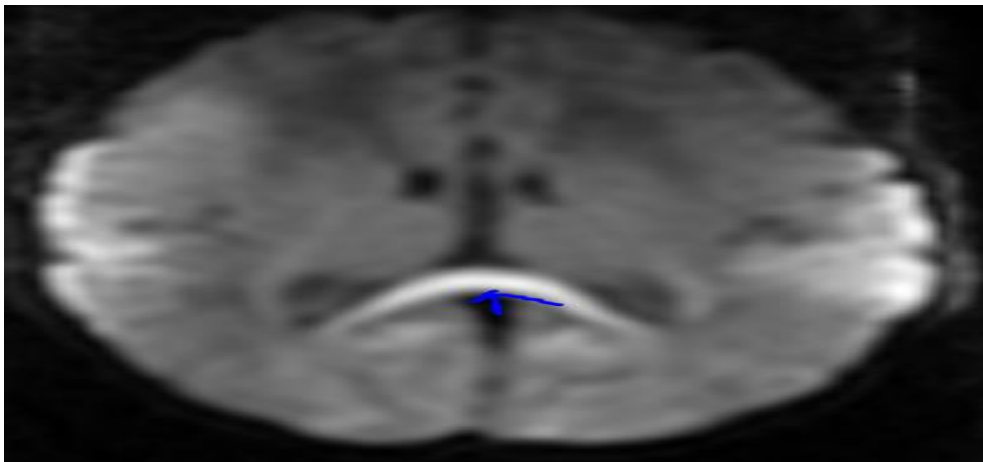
Axial Diffusion Weighted Image of Brain MRI: Predominant Corpus callosum involvement in term neonate with Hypoglycaemic Brain Injury.
